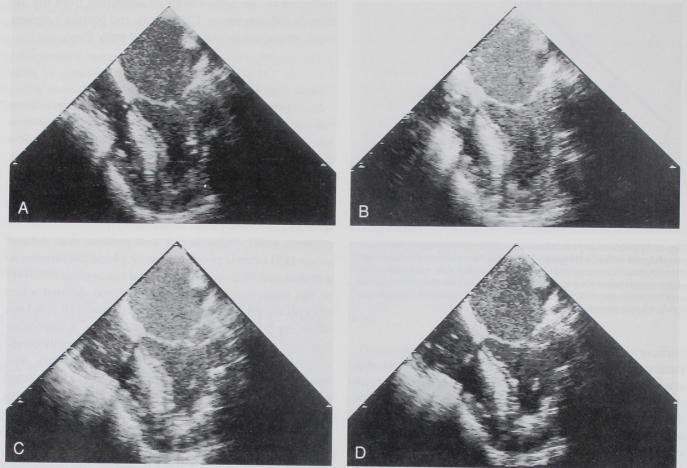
(A) Two-dimensional mid-atrial, four-chamber transesophageal echocardiogram of the myocardium, obtained immediately before antegrade contrast injection. (B) Same image obtained immediately after antegrade contrast injection. Note opacification within the myocardium is beginning to appear in the septum, the right ventricle, and the apex. (C) The same image recorded a few frames later showing the appearance of contrast washout in the apical region of the myocardium and the right ventricular free wall. (D) The same image a few more frames later (approximately 9 s after injection). The image now shows the contrast washout effect in the apical, septal, and right ventricular regions.
